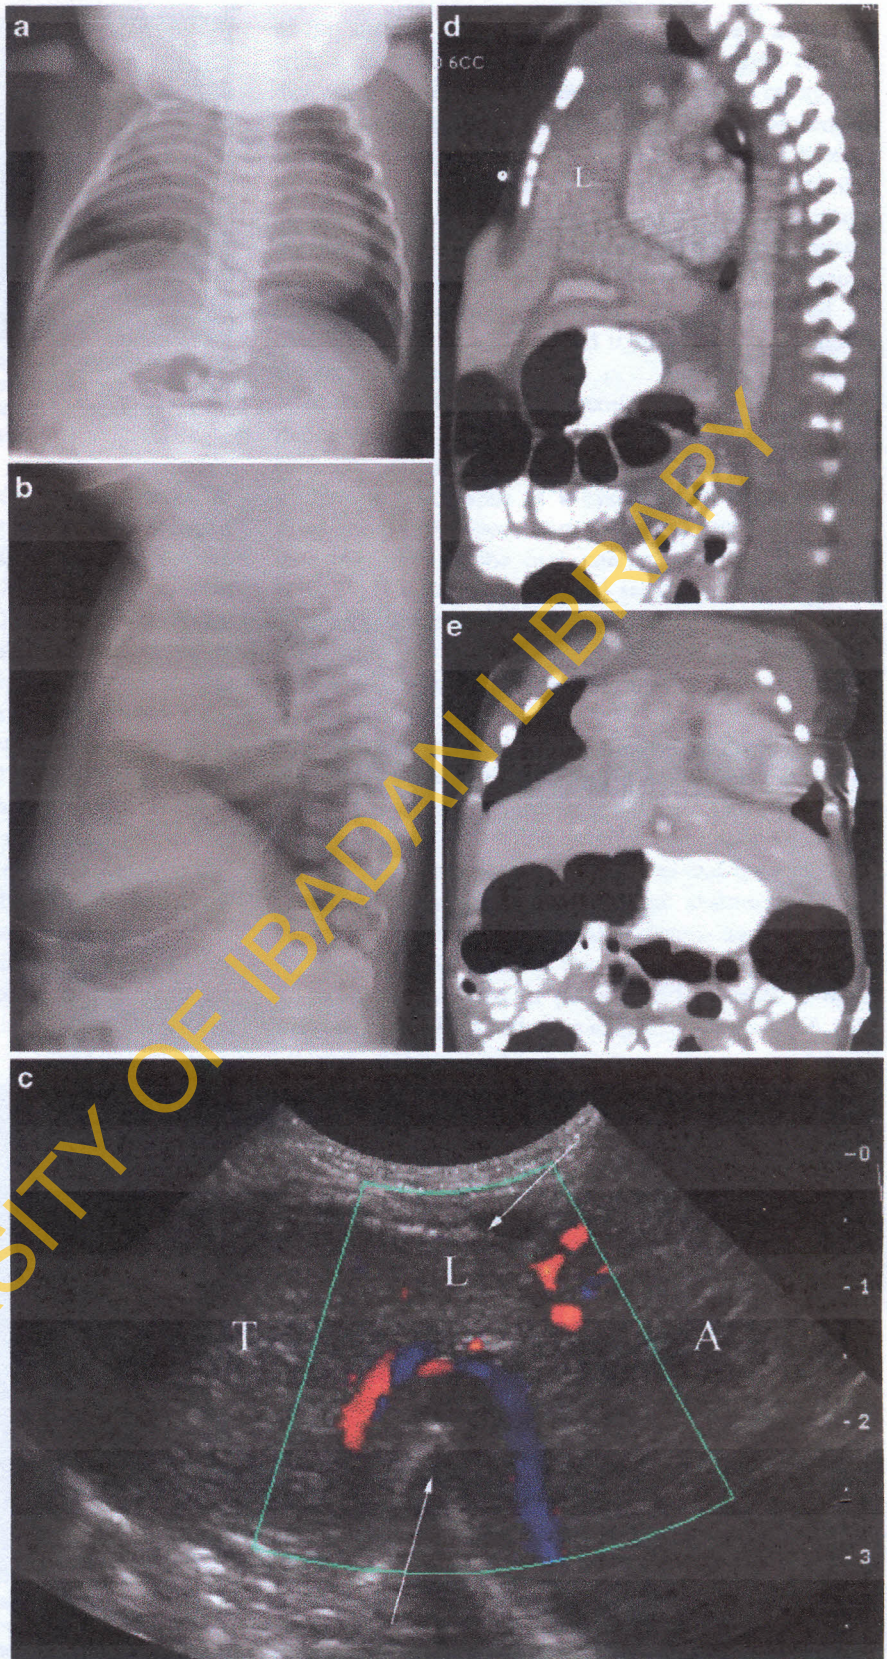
A 7-day-old boy with a Morgagni hernia. a, b Antero-posterior (a) and lateral (b) chest radiographs show a poorly defined right chest mass and right upper lung atelectasis. c Sagittal color Doppler sonogram of the right chest obtained on the same day shows herniation of the liver (L) through an anterior foramen of Morgagni hernia (*arrows*). Note the abnormal course of the hepatic vein and the difference in echotexture of the intrathoracic (T) and intraabdominal (A) portions of the liver. d, e Sagittal (d) and coronal (e) contrast-enhanced CT reconstructions obtained the same day confirm anterior liver (L) herniation
